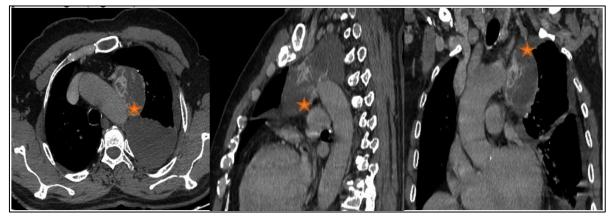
Chest CT in axial section post contrast showing initially peripheral nodular enhancement. (Orange star)
